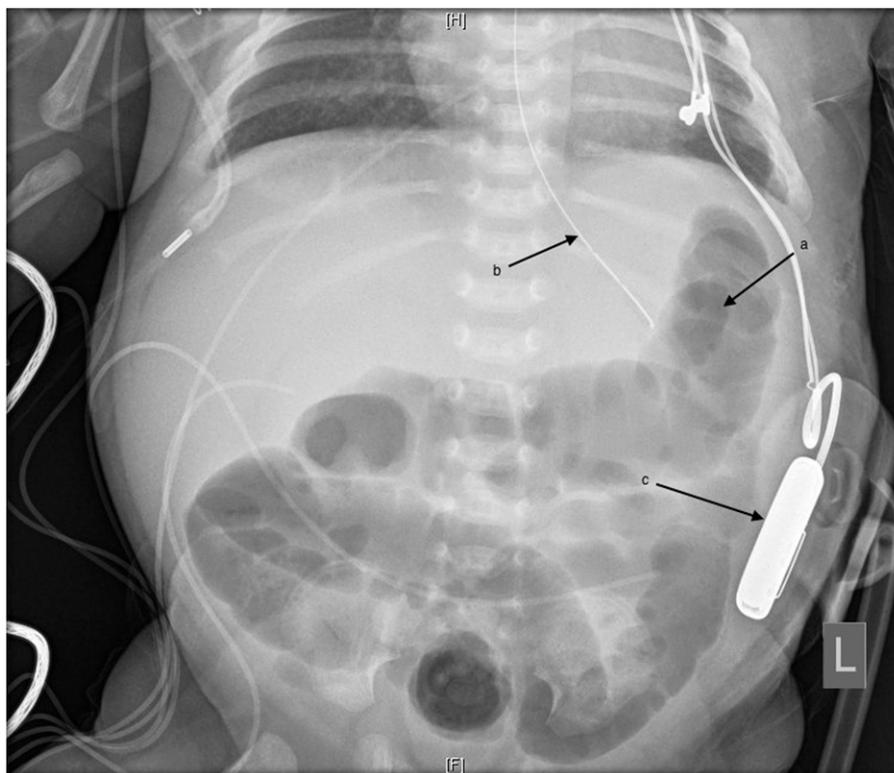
Repeated radiograph 24 hours after the previous radiograph and 12 hours after the initiation of gastric lavage demonstrates normal gaseous distention of the gastric fundus without lucency, consistent with resolution of lactobezoar (a). A nasogastric tube (b) and cardiac pacemaker (c) are present.
